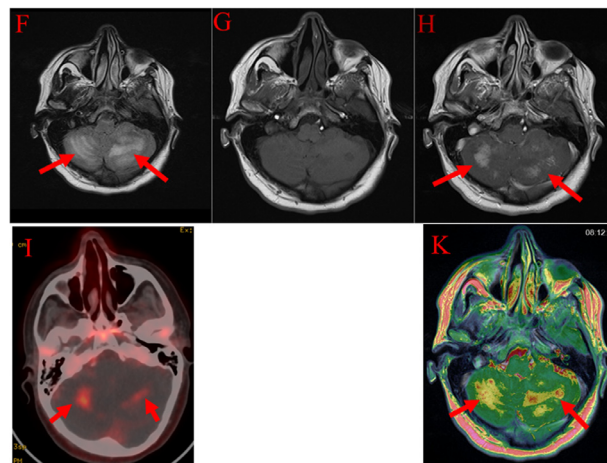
Axial images at the level of cerebellum: Flair (F), T1 WI MR pre (G), and post contrast (H), fused ^{18}F Choline PET/CT (I) and fused ^{18}F Choline MR (K) are showing hyperintensity lesion red arrows in (F) with contrast enhancement and choline activities.
